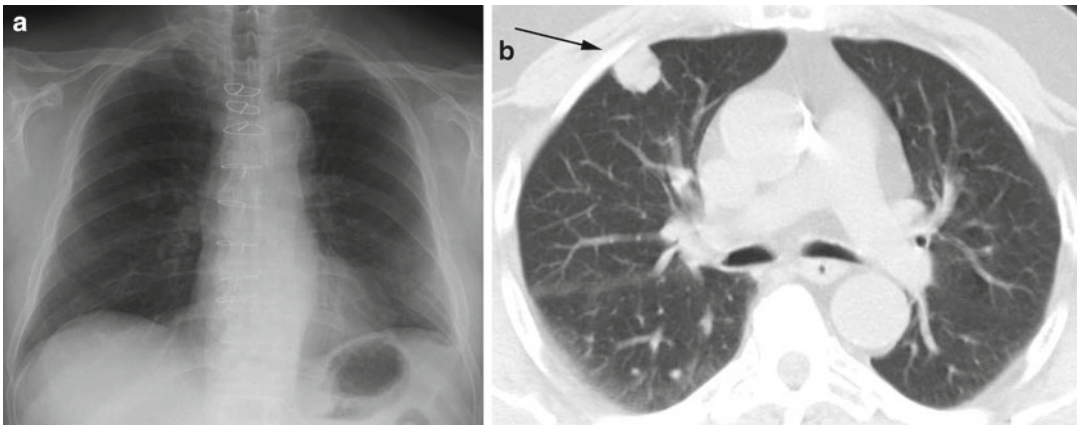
(a, b) Small cell carcinoma (SCLC) presenting as a solitary pulmonary nodule (SPN). CT reveals slightly lobulated right upper lobe nodule (*arrow*). There are no
